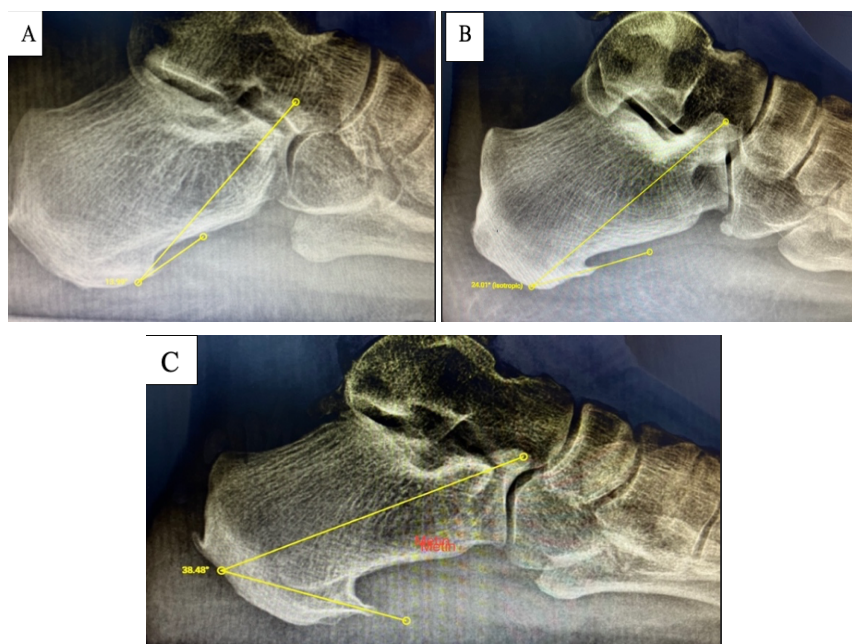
Sample lateral radiography images of the plantar calcaneal spurs taken by stepping; a) angulation of 13 degrees (type A), b) angulation of 24 degrees (type B), c) angulation of 38 degrees (type C).
